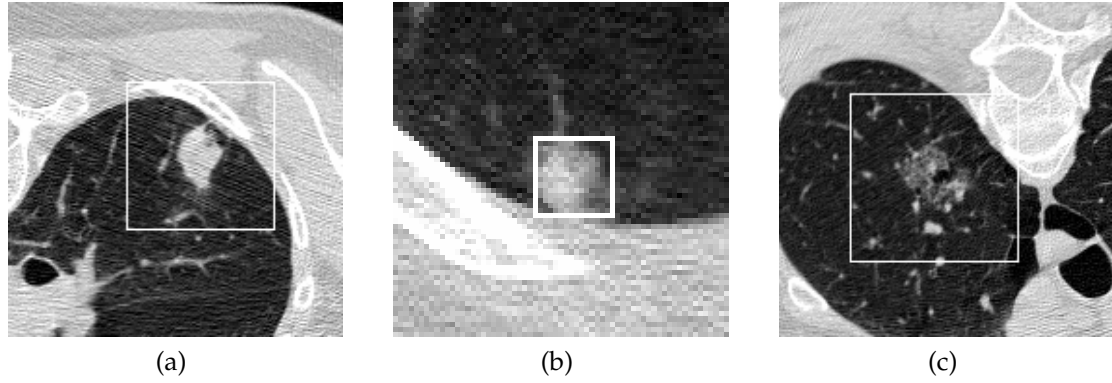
Examples of a) solid, b) part-solid, and c) non-solid nodules on a single slice of a CT scan, with the nodule indicated by a white box. Images are shown at different magnification levels.
